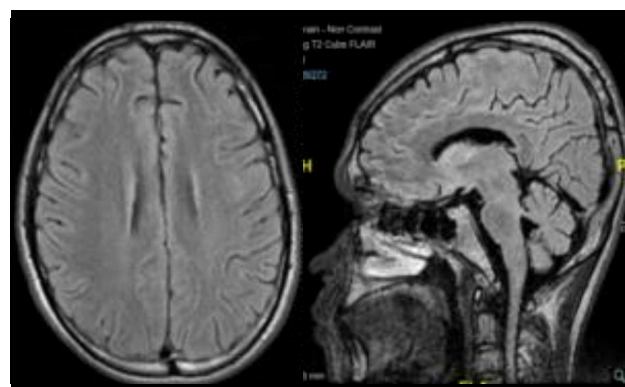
T2-weighted axial dan sagittal FLAIR showed no hyperintensity at the body of corpus callosum after 5 days after administration of UCMSCs.
